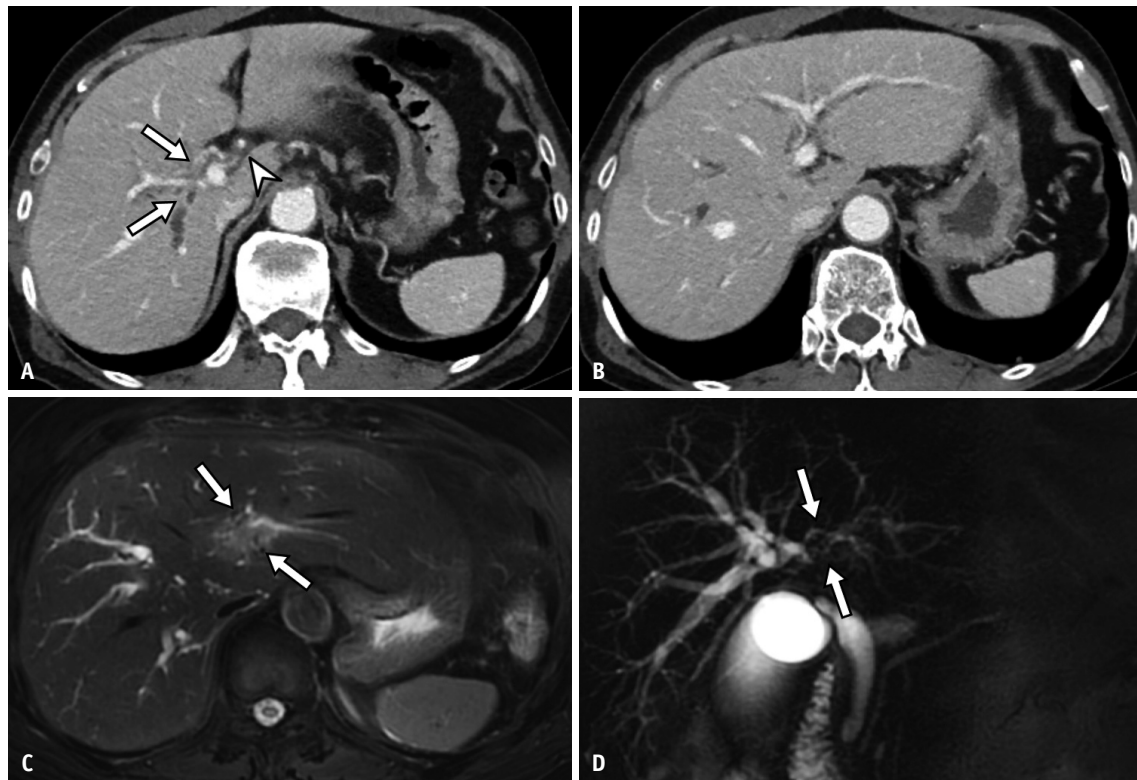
A 66-year-old male patient with biopsy-confirmed perihilar cholangiocarcinoma. On CECT, axial portal venous phase images (A, B) show wall thickening and enhancement of the common hepatic duct and right secondary confluence (A, arrows) and soft tissue around the right hepatic artery (A, arrowhead). B: The left hepatic duct is minimally dilated, and the secondary confluence separation is not evident. Two reviewers rated this case as “indeterminate” resectability, while the other reviewers rated it as “probably” unresectable. On CE-MRI with MRCP, which was performed 12 days later, the axial T2-weighted and MRCP images (C, D) of CE-MRI with MRCP show the tumor involving the left secondary confluence as well (arrows). All reviewers determined this case as “definitely” unresectable on both CE-MRI with MRCP and the combined review of CECT and CE-MRI with MRCP. The patient did not undergo surgery based on the decision made in the multidisciplinary team conference. CECT = contrast-enhanced computed tomography, CE-MRI = contrast-enhanced magnetic resonance imaging, MRCP = magnetic resonance cholangiopancreatography
